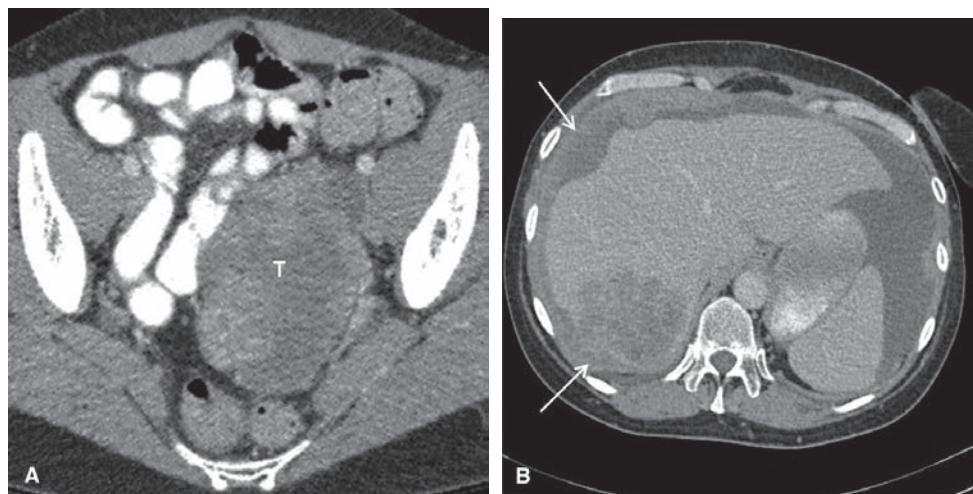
Recurrent ovarian carcinoma. Contrast-enhanced CT images in a patient with a previous history of ovarian cancer. A large solid mass is seen in the right adnexa (T in A). Multiple peritoneal deposits are seen in the undersurface of the right hemidiaphragm as well as a large subserosal liver deposit with deep invasion into the liver parenchyma (arrows in B).
